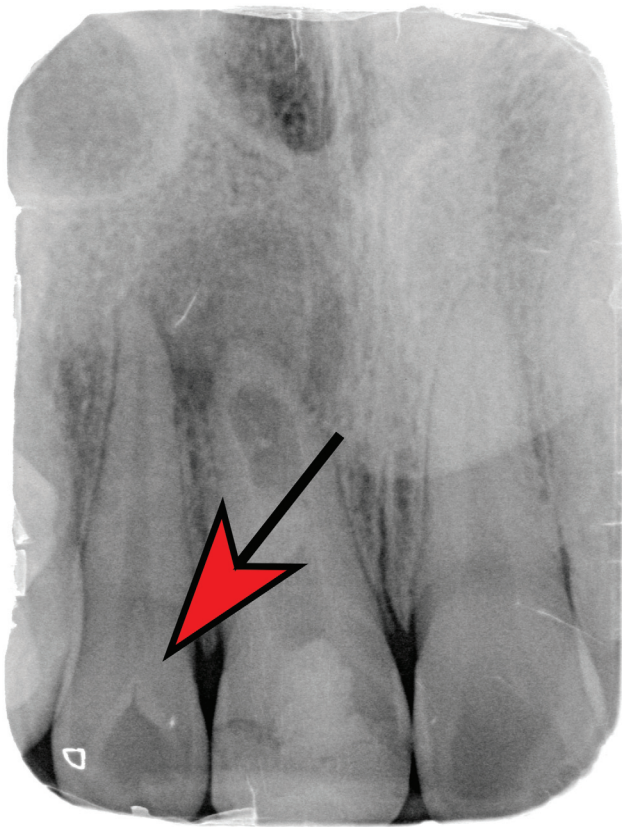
Teeth with dens invaginatus may present as asymptomatic, with little external deformity, but may become apparent on radiographs as incidental findings.
